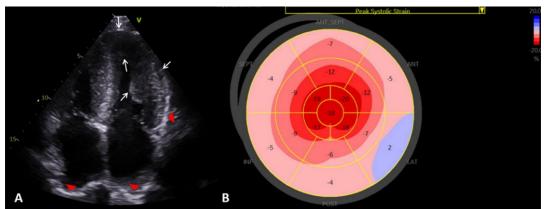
Echocardiography findings in a patient with cardiac transthyretin type amyloidosis: Four chamber view (A) showing granular sparkling texture of the myocardium (red arrow head), concentric left ventricular hypertrophy (white arrows) and atrial dilatation. (B) Left ventricular longitudinal strain.
